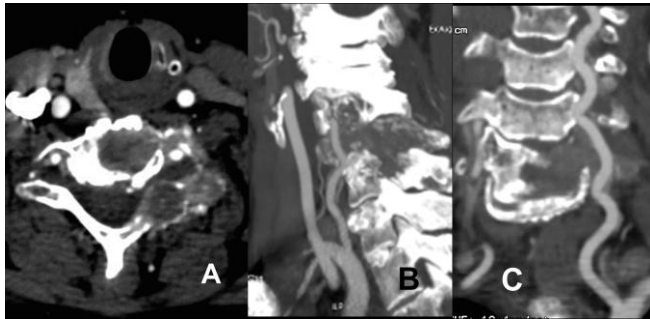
a and b - CT axial (a) and sagittal (b) images showing the C5 osteolytic metastasis involving the left VA, C5 body and partially C6.
